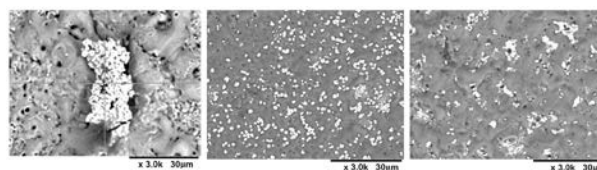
SEM pictures of the surface of titanium discs (3000x magnification). Left: without ultrasound; middle: 27 kHz; right: 80 kHz. Copper appears as white spots.
